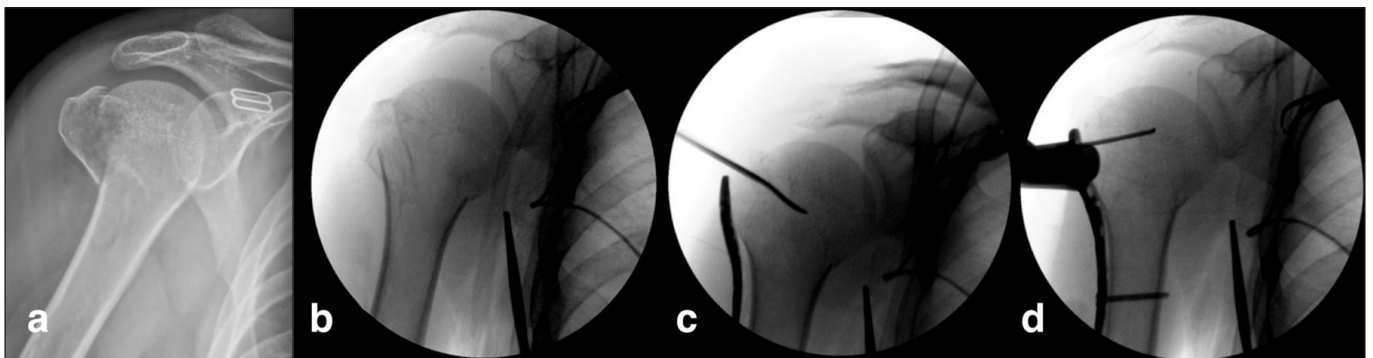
Patient with Neer type III proximal humerus fracture a pre-operative X-ray (a), intra-operative fluoroscopy views, preliminary reduction under traction (b), a proximal humerus plate is inserted, then calcar continuity provided by elevator (c), one cortical screw is placed distally and locking screws are placed into head (d).
